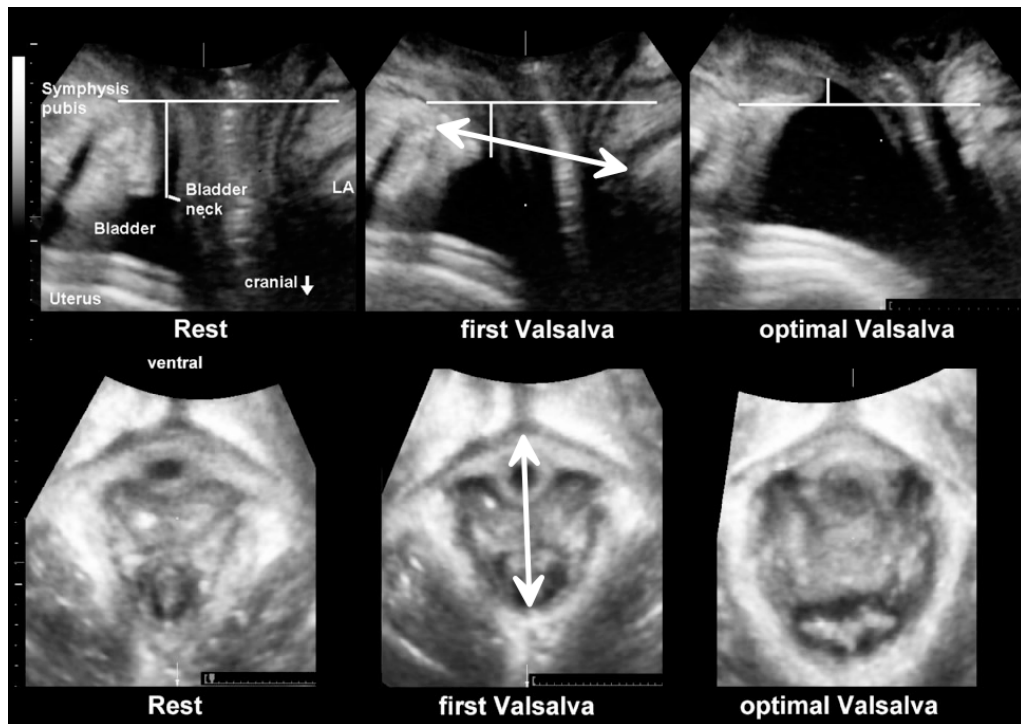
Levator co-activation or co-contraction during Valsalva evidenced by a reduction in anteroposterior hiatal diameter (first Valsalva, vertical lines in central images). From Oerno et al., Ultrasound Obstet Gynecol 2007; 2007; 30: 346–350
